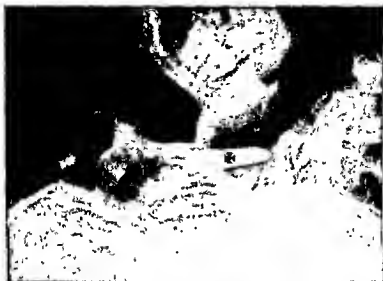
Roentgenogram of the head in the inverted position, before suction. The radiopeque lies in the nasal chamber and does not enter the sinuses.
